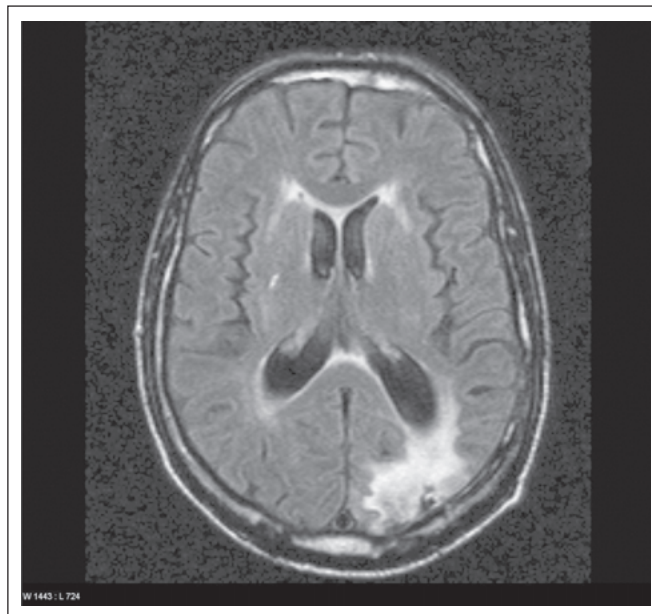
Axial FLAIR-MRI.
